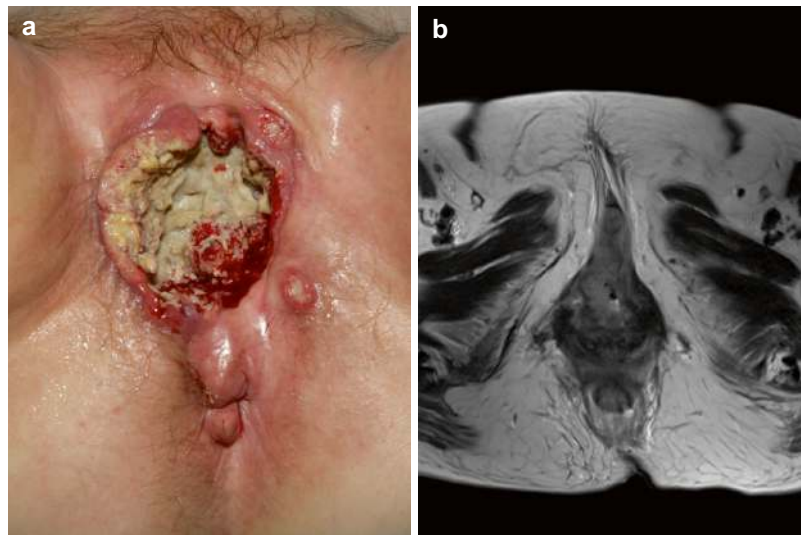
oT3b vulvar carcinoma infiltrating tissues matured from the urogenital plate morphogenetic field. (a) Photograph of a vulvar carcinoma involving the labia majora, urethra, and erectile structures. (b) T2-weighted transverse MRI scan showing a vulvar carcinoma infiltrating the corpus and crura of the clitoris
